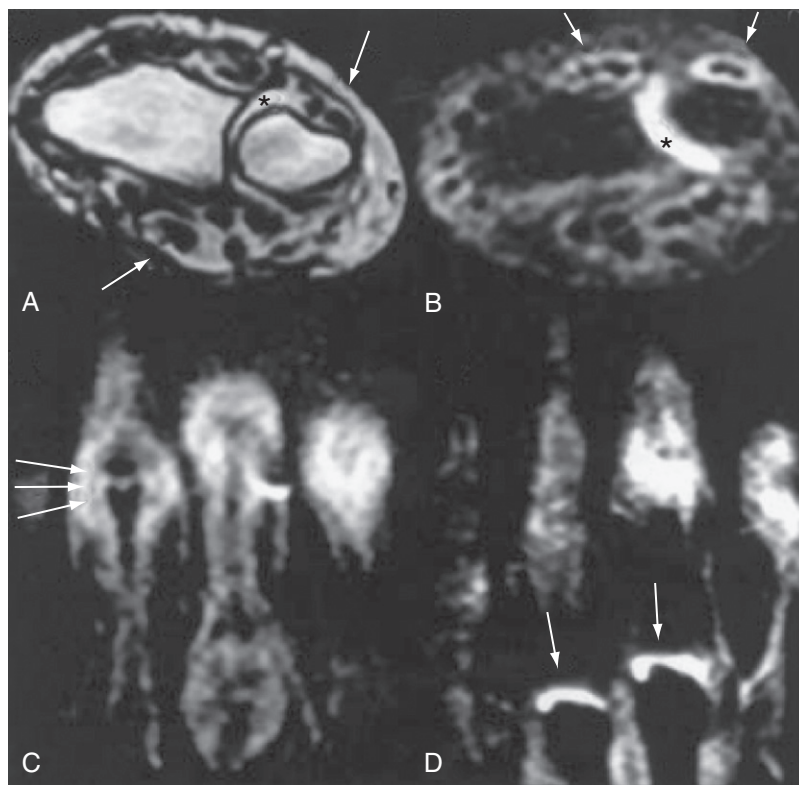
Hand magnetic resonance images of two females aged 25 and 32 with mixed connective tissue disease and hand arthritis. A, Patient 1 has synovitis/effusion around the ulnar styloid (asterisk) and tenosynovitis of the flexor and extensor tendons (arrows) (T1-weighted gadolinium-enhanced sequence on axial plane). B, Patient 2 has intense synovitis of the radioulnar joint (asterisk) and extensor tenosynovitis (arrows) causing thickening of the dorsum of the hand (T1-weighted short tau inversion recovery [STIR] sequence on axial plane). C, Patient 1 has synovitis/effusion, and pericapsular edema is seen in the second proximal interphalangeal joint. The distended capsule is indicated by arrows. D, Patient 2 has intracapsular synovial effusion or synovitis of the third and fourth metacarpophalangeal joints (arrows). (Both C and D are T1-weighted STIR sequences in the coronal plane.) (From Cimmino MA, Lozzelli A, Garlaschi G, et al: *Magnetic resonance imaging of the hand in mixed connective tissue disease*, *Ann Rheum Dis* 62:380–381, 2003.)
